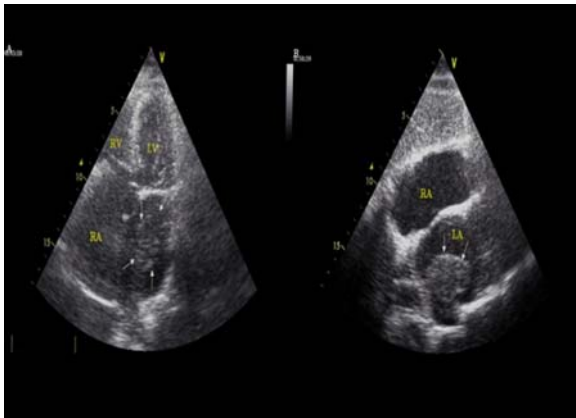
Two dimensional echocardiography images revealed a left atrial myxoma attached to the left lateral atrial free wall (marked by arrow, 1-A, apical four chamber view; 1-B, subcostal view) LA: left atrium, LV: left ventricle, RA: right atrium, RV: right ventricle.
